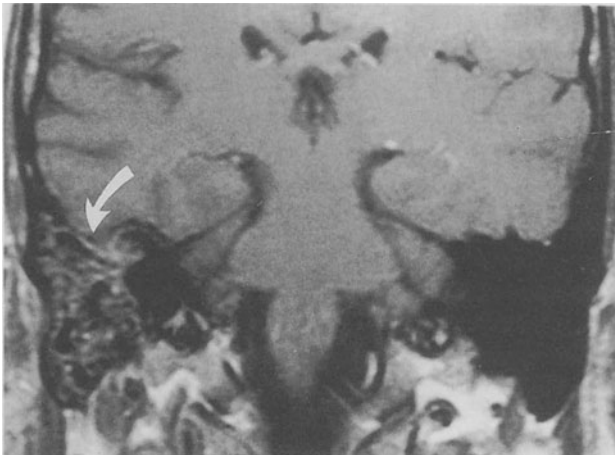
Acute mastoiditis with dural involvement in a 53-year-old man. T1-weighted coronal MR image obtained after IV administration of paramagnetic contrast agent shows abnormal enhancement of both thickened mucosa of right mastoid air cell system and dura above tegmen tympani (*arrow*). (Courtesy of Klaus Sartor and Marius Hartmann, Heidelberg)
